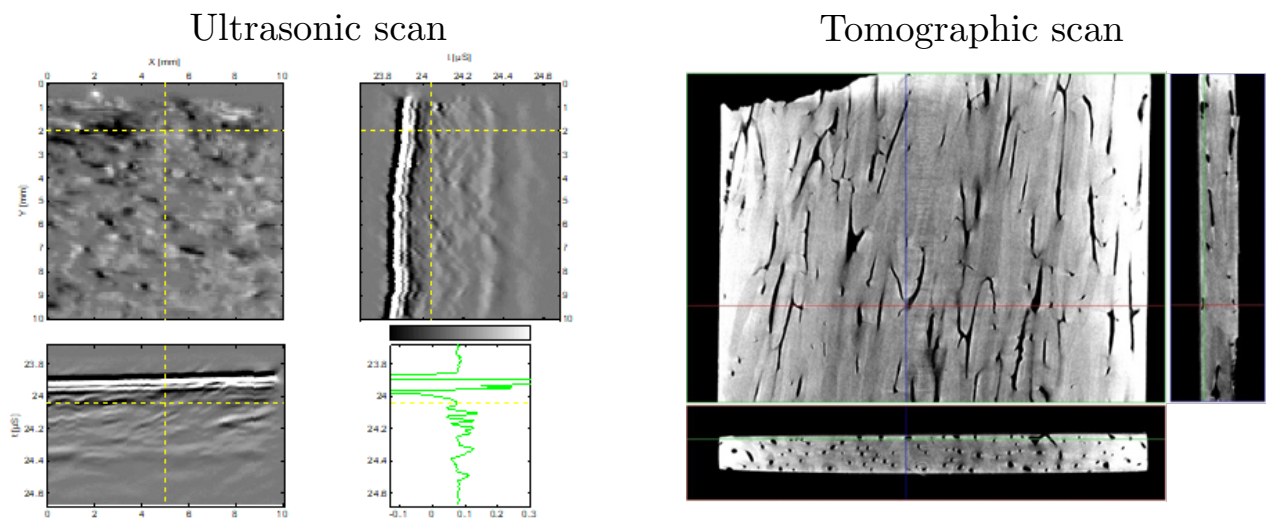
Comparison of an ultrasonic scan (left) and a tomographic one (right)
